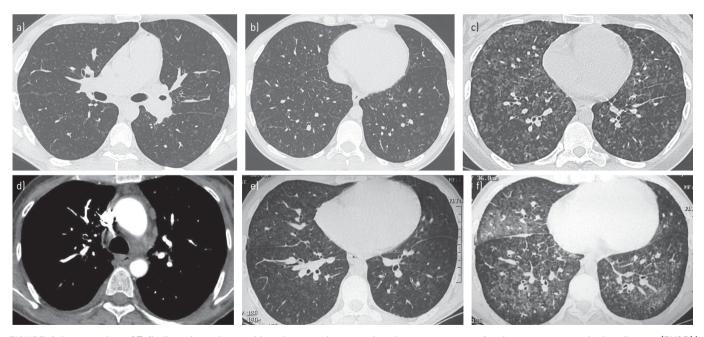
Images show CT findings in patients with pulmonary hypertension due to presence of pulmonary veno-occlusive disease (PVOD)/ pulmonary capillary haemangiomatosis (PCH). a) Transverse CT section at level of right and left main bronchi from noncontrast examination in a 45-year-old woman shows centrilobular lung nodules in both lungs with enlarged left hilum due to underlying lymphadenopathy. b) Same examination as that shown in (a). Transverse CT section obtained at level of lower lobes shows bilateral centrilobular nodules seen and thin septal lines in right lower lobe. c) Transverse CT section at level of lower lobes from noncontrast examination obtained in a 51-year-old woman shows profuse nodular ground-glass opacities. d) Transverse CT section at level of carina from chest CT angiographic study obtained in a 35-year-old woman shows mediastinal lymphadenopathy. e) Transverse CT section at level of lower lobes from noncontrast examination in a 61-year-old woman before treatment. Note presence of centrilobular nodules in both lungs. f) Transverse CT section at same level as that shown in (e) (same patient); noncontrast chest CT examination obtained 6 weeks after initiation of endothelin receptor antagonist shows CT features of pulmonary oedema.
